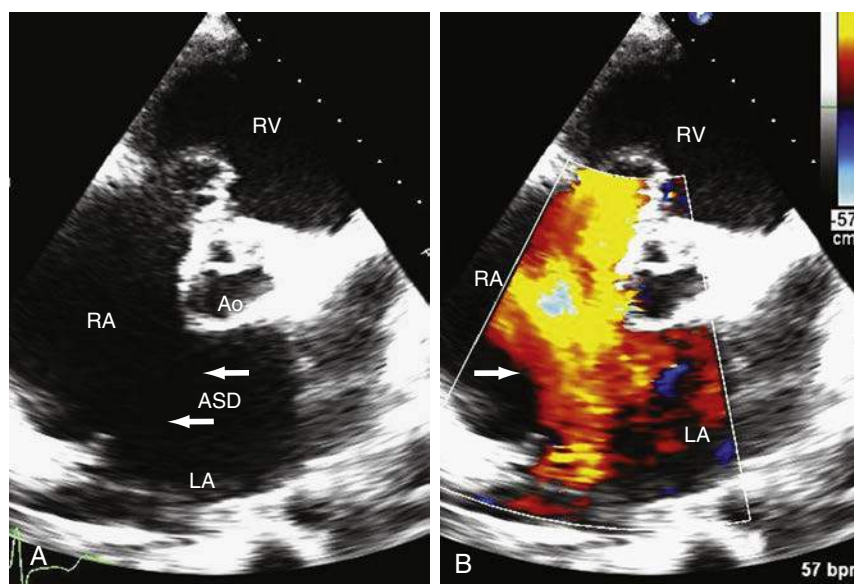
A, Two-dimensional transthoracic echocardiogram (2D TTE) from the parasternal short-axis view at the level of the aortic valve showing a large secundum ASD (white arrows). The RA is enlarged. B, Color Doppler showing a large left-to-right shunt (white arrows). Ao, Aorta; ASD, atrial septal defect; LA, left atrium; RA, right atrium; RV, right ventricle.
